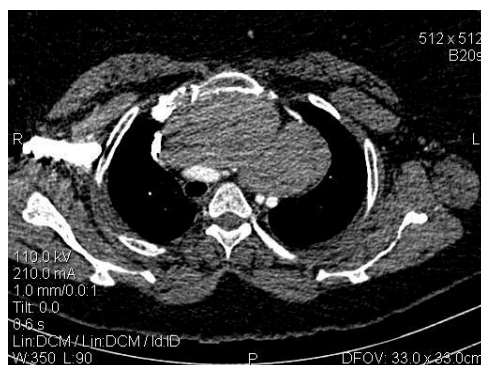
CT appearance showing an endothoracic mass with tracheal deviation
